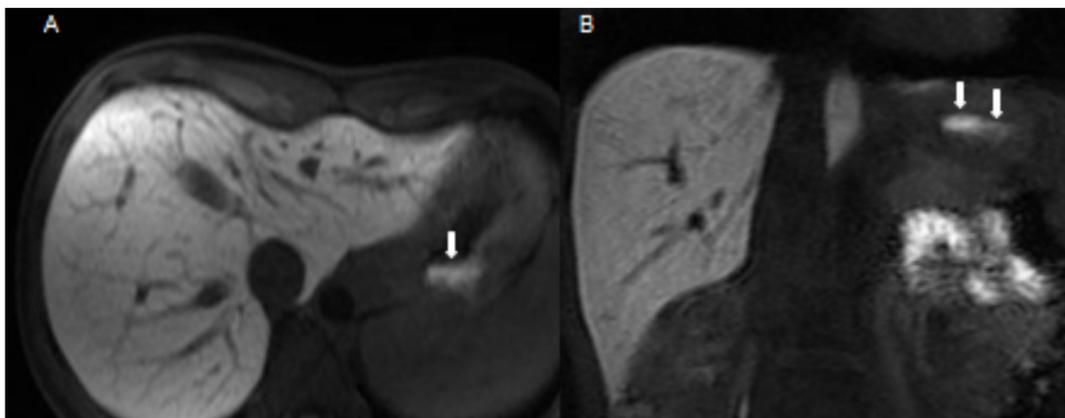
Axial (A) and coronal (B) gadoxetic-acid enhanced T1-weighted MR images of a 24-year-old female patient. Duodenogastric reflux into the gastric fundus in the delayed phase (75 min after injection). Upper endoscopy revealed erythematous gastritis but no bile reflux. Biopsy proved chemical gastritis
